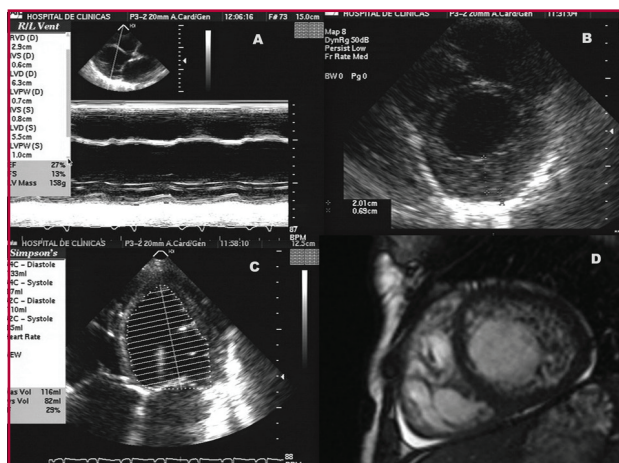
Echocardiographic image showing left ventricular dilatation (A) and severe left ventricular dysfunction (B). Short-axis echocardiographic views (C) and magnetic resonance imaging (D) showing non-compacted myocardium.
